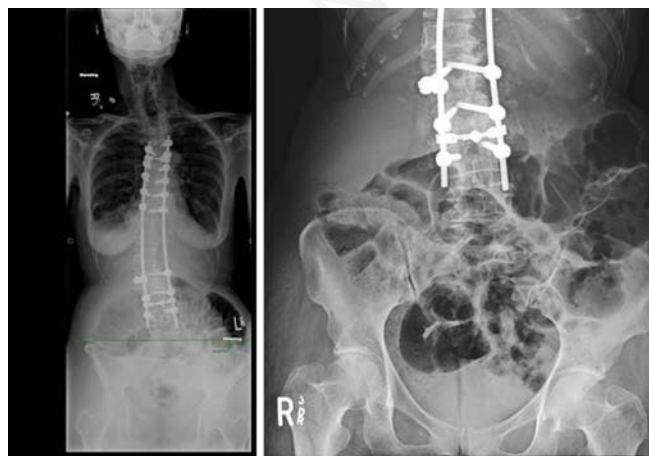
Postoperative radiograph after the patient's first operation showing the presence of air-filled, dilated bowel loops consistent with paralytic ileus.
